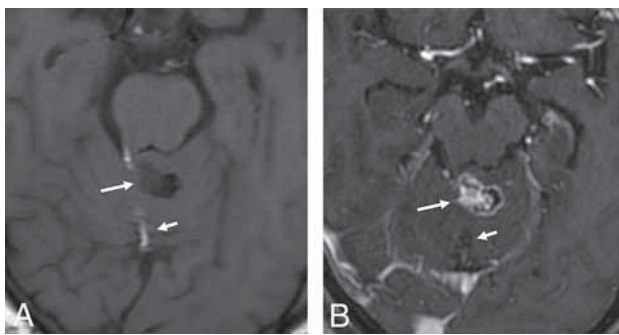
Cerebellar liponeurocytoma in a 71-year-old woman with transient neurologic deficits. A heterogeneously enhancing nodule (long arrow) in the superior vermis associated with a linear component compatible with macroscopic fat (short arrow). Axial T1-weighted image (A). Axial T1-weighted fat-saturated contrast-enhanced image (B).
